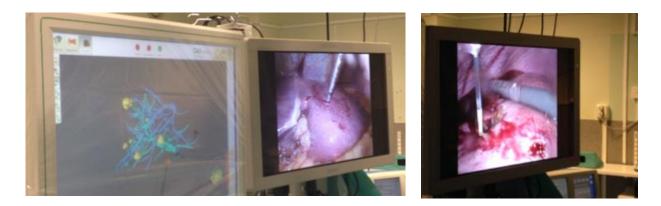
Optical navigated laparoscopic microwave ablation of multiple liver metastases from colorectal cancer, verified with ultrasound assistance, performed at Danderyd Hospital.
